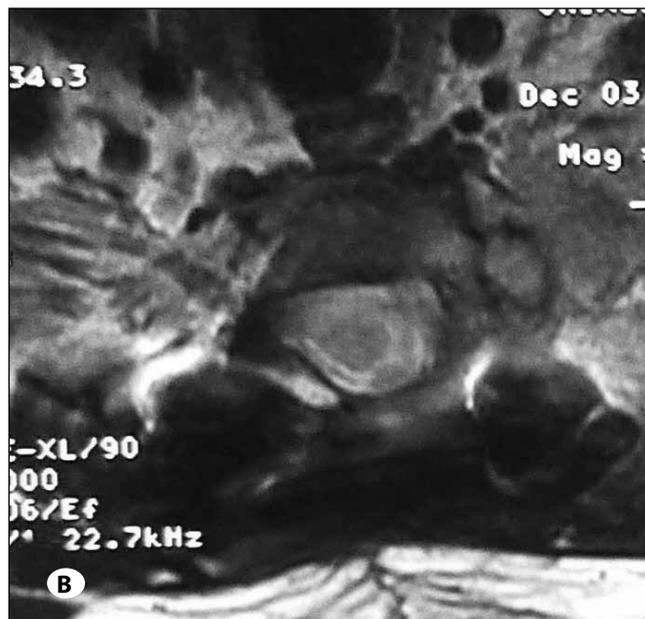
Postoperative T2-weighted magnetic resonance image scan in the A) sagittal and B) axial planes revealing decompression of the spinal cord and no indication of recurrence.
